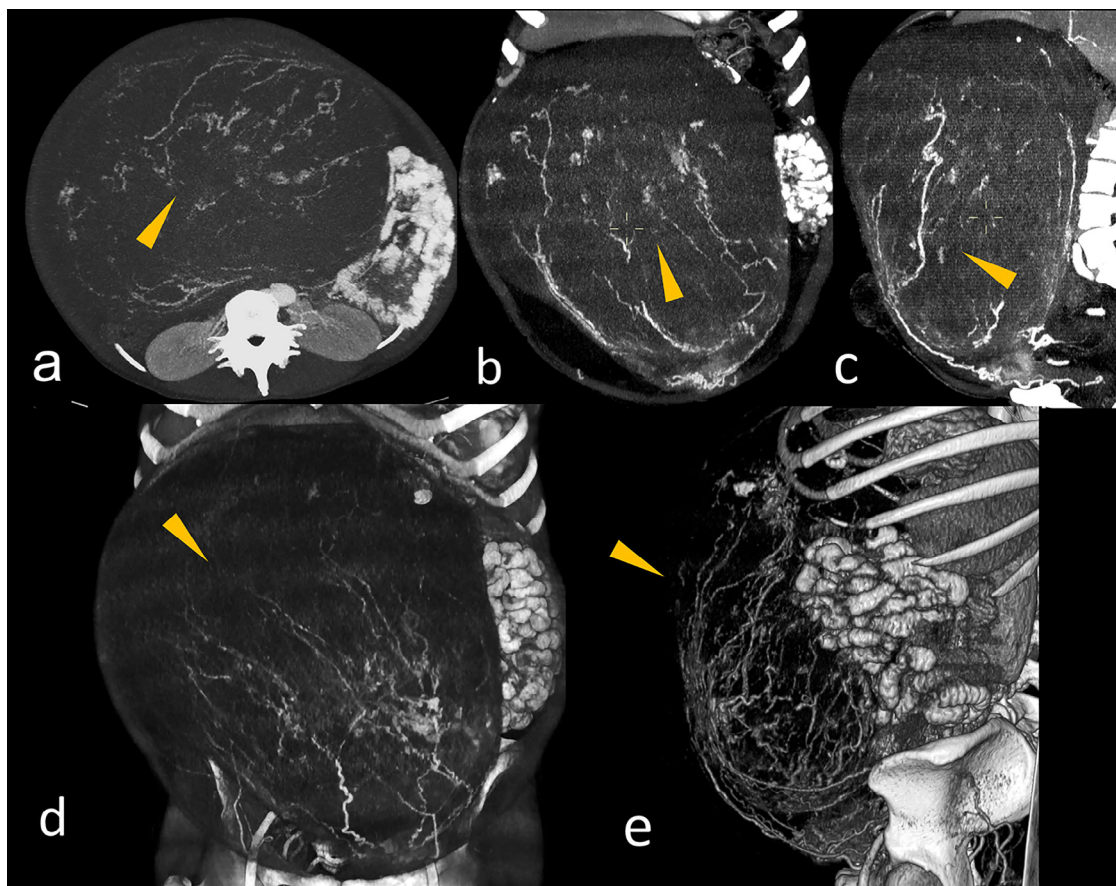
Axial (A), coronal (B), and sagittal (C) computed tomography (CT) maximum intensity projection (MIP) images showing multiple vessels crossing the abdominal mass. CT coronal (D) and sagittal (E) volume-rendered image provides good 3D definition of the vascular distribution within the mass.
